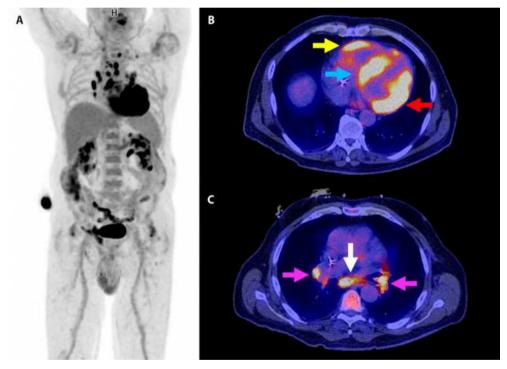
(A) Whole body FDG-PET/CT performed following myocardial suppression protocol (24h high-fat, low-carbohydrate diet, 12h fasting, intravenous heparin). (B) Intense patchy FDG uptake (SUVmax=15.4) was present within the myocardium at the levels of the left ventricular free wall (red arrow), interventricular septum (blue arrow) and right ventricle (yellow arrow). (C) Increased FDG uptake (SUV-max=14.9) was present within multiple intrathoracic LN, notably in the hilar (pink arrows) and subcarinal (white arrow) regions.
